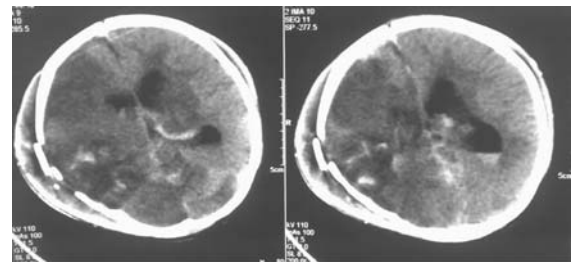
CT scan showing right fronto parietal elevated fracture with underlying contusion
